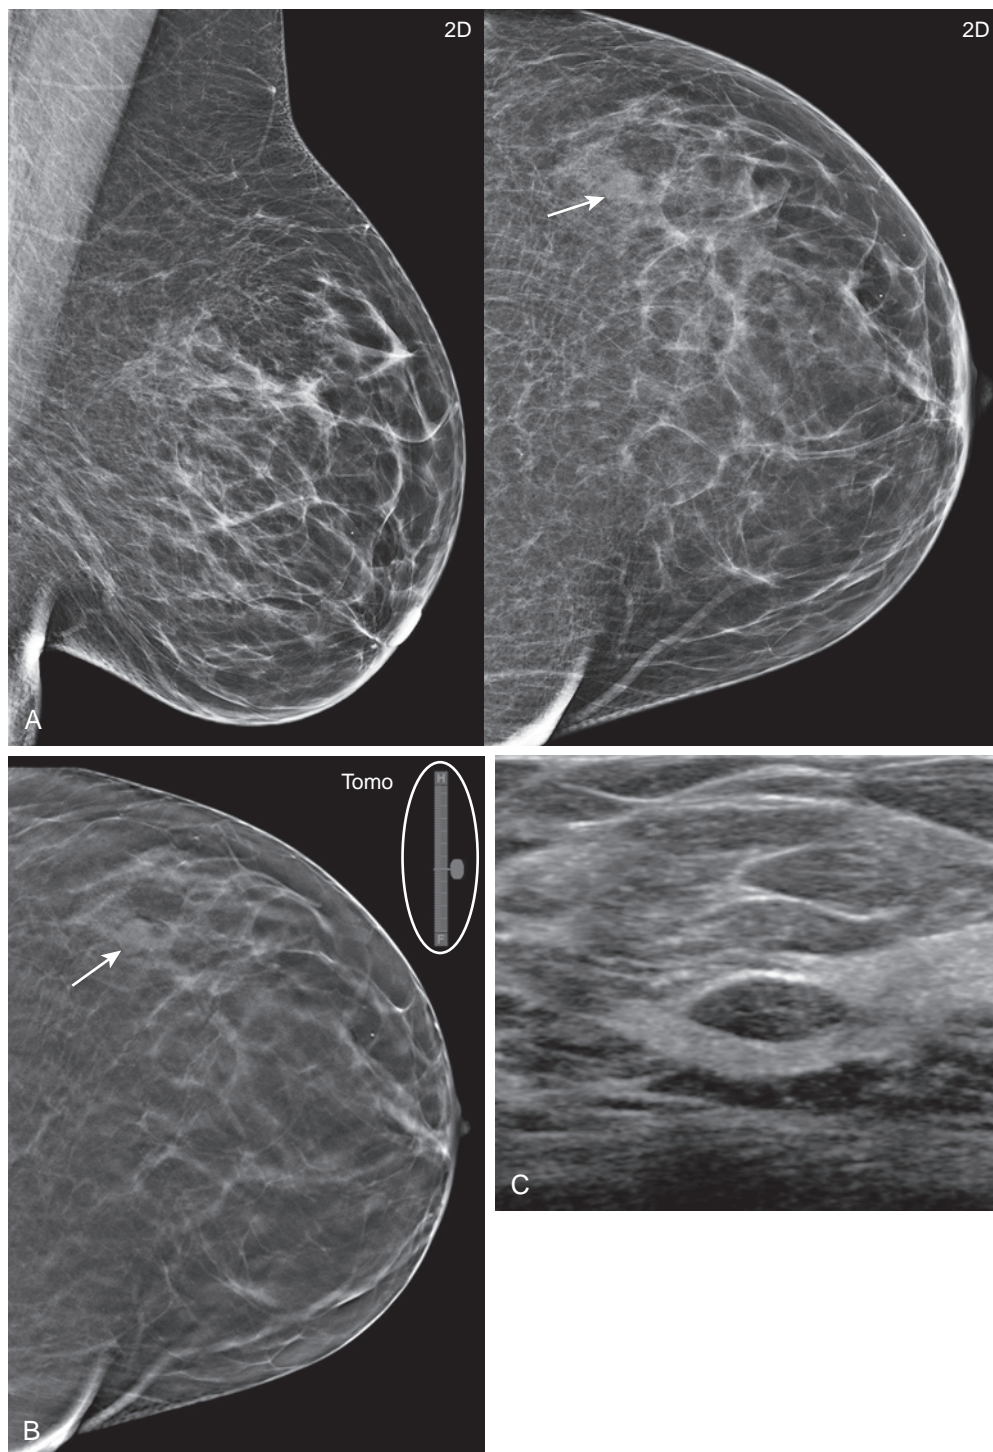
Fibroadenoma only seen on CC view (A) Two-dimensional left MLO and CC views show subtle suggestion of a mass (*arrow*) in the lateral left breast in the CC view (*arrow*), with no corresponding finding in the MLO view. (B) Tomosynthesis confirms a circumscribed mass in the lateral left breast on the CC view. No corresponding finding is seen in the MLO view even on tomosynthesis (not shown). However, the position of the CC tomosynthesis slice on the adjacent sliding scale (*circle*) shows the mass to be located in the mid-portion of the superior-inferior dimension. (C) Targeted ultrasound to the location indicated on tomosynthesis shows a corresponding oval circumscribed hypoechoic mass at the 2-o'clock position, likely representing a fibroadenoma; it was assessed as BI-RADS 3 and stable on follow-up.
